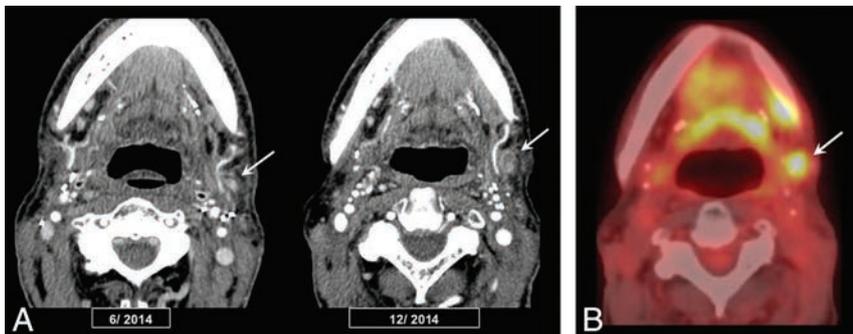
NI-RADS neck category 3: new or enlarged lymph node. T2N0 oral cavity squamous cell carcinoma status post resection, neck dissection, and adjuvant radiation therapy. *A*, CECT at 6-month intervals shows enlarging left level 1B lymph node with necrosis (*arrows*). *B*, Fused PET images show marked focal FDG uptake (*arrow*). Revision neck dissection was positive for disease recurrence.
